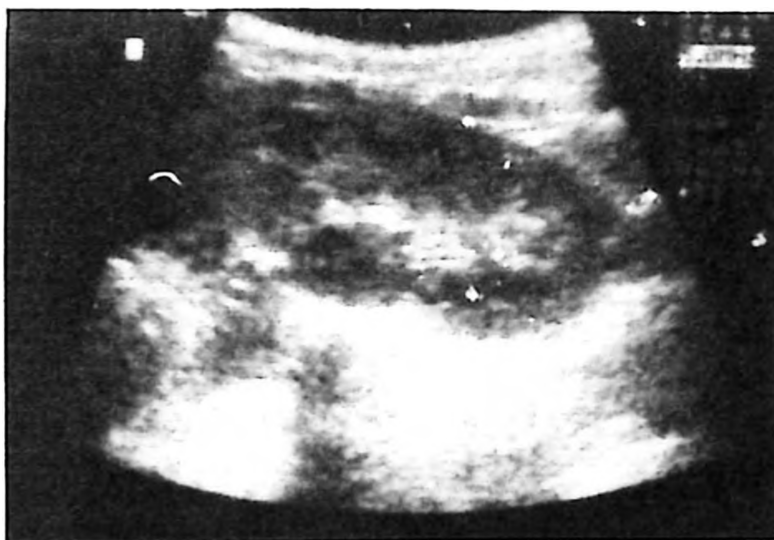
Ultrasound scan demonstrating normal pelvicalyceal system after therapy.
